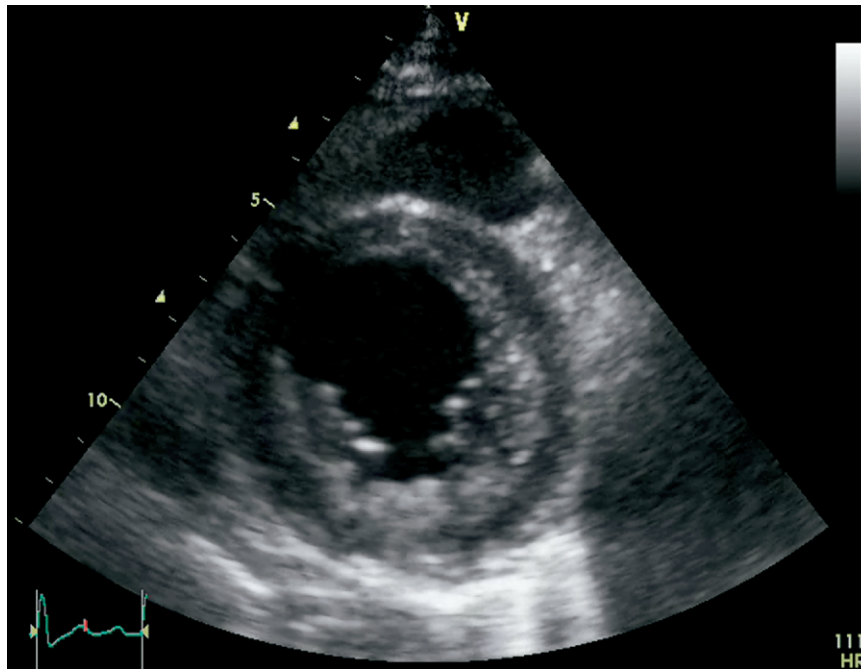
Two-dimensional echocardiogram (short-axis view) showing prominent trabeculations and recesses in noncompacted portion of left ventricle.
